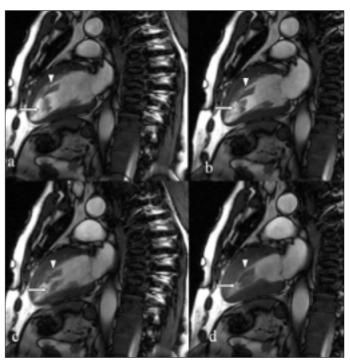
In two- chamber magnetic resonance imaging cine view (a-d), arrowheads show immobile masses derived from anterior wall and arrows show mobile, pedunculated masses derived from diaphragmatic wall in systole and diastole
